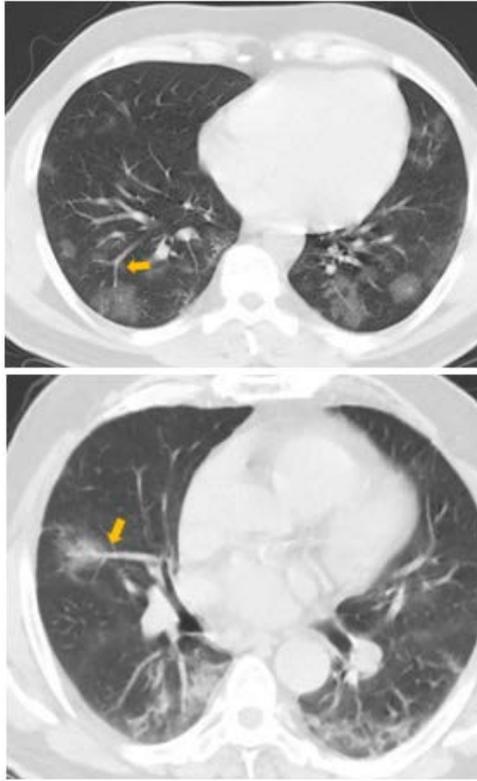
a) Vascular enlargement sign in a 38-year-old man with COVID-19 who presented with persistent fever and cough. Axial chest CT image shows multifocal bilateral areas of GGD with vascular enlargement (yellow arrow). b) 41-year-old man with COVID-19 patient presenting with fever. Axial CT scan shows bilateral ground-glass densities and vascular enlargement sign in the right middle and lower lobes (yellow arrow).
